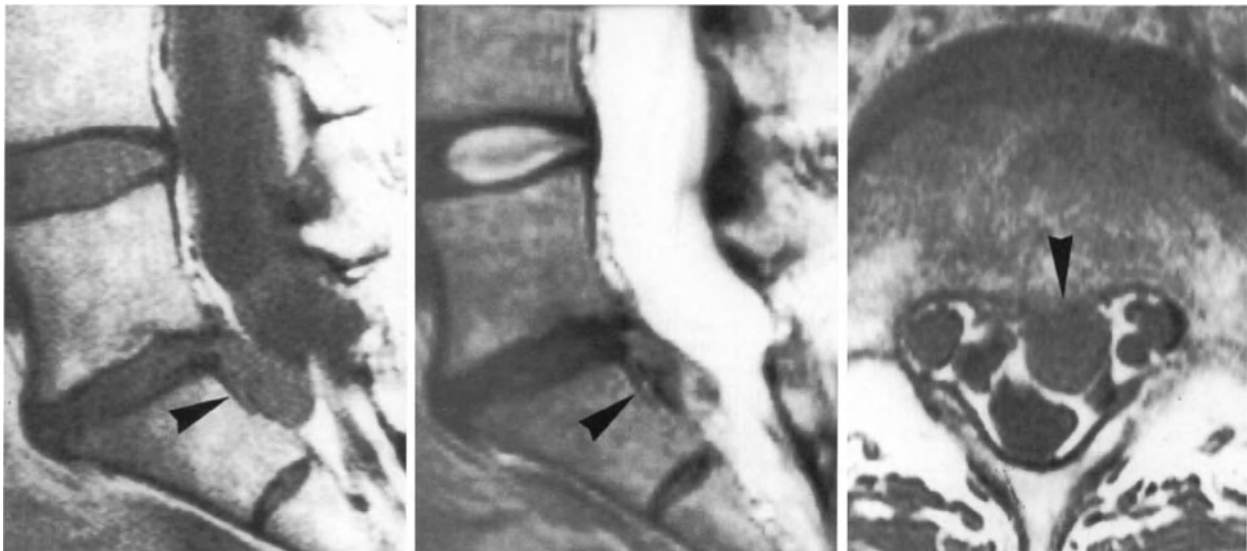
Sagittal and axial MR images of a 37-year female with large midline disc herniation migrated caudally (arrowheads). Symptoms gradually disappeared over a 40-day period with medical anti-inflammatory therapy (steroids for 10 days and then NSAIDs for 2 weeks) and physiotherapy (massage, TENS and magnetic field therapy for 3 weeks).
